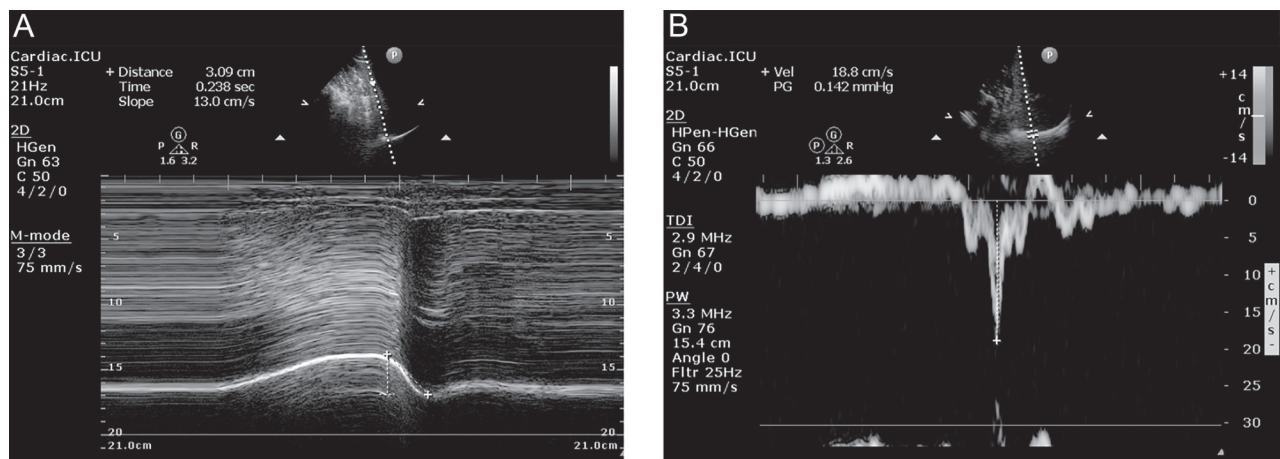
M-mode ultrasonographic measurement of A: passive cephalic excursion of the diaphragm; and B: diaphragm peak velocity by tissue Doppler ultrasonography during the cough expiratory phase.
